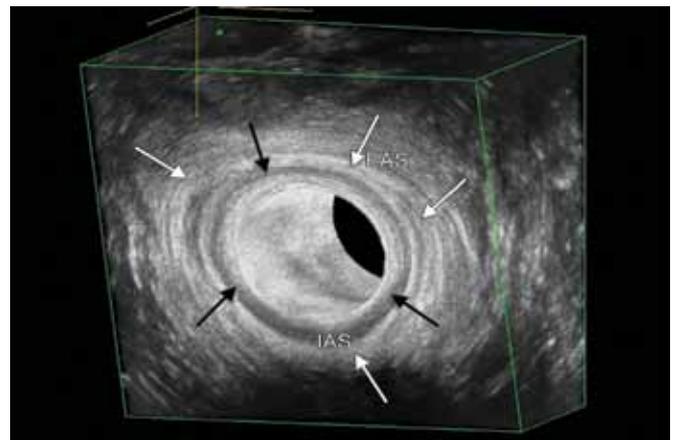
Three-dimensional-endoanal ultrasound of the anal canal showing the hypoechoic IAS (white arrows) and the hyperechoic EAS (black arrows)
